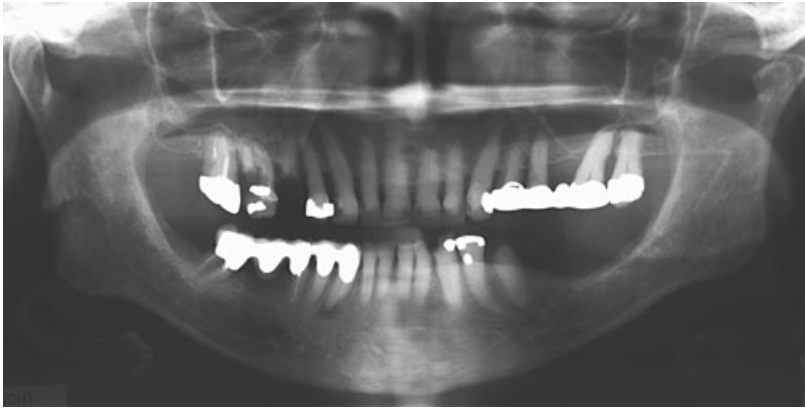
Panoramic radiograph supporting the full-mouth radiographs shown in Fig. 27-1b.
